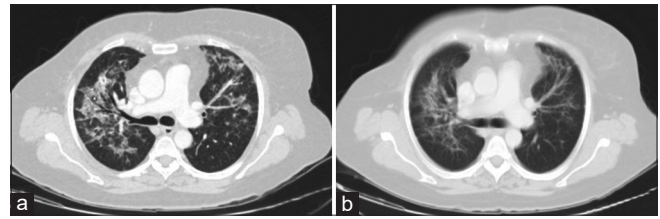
High-resolution computed tomography images of residual response to steroid in taxane-induced interstitial lung disease. (a) Baseline high-resolution computed tomography of the thorax showing drug induced interstitial pneumonitis following docetaxel with interstitial septal thickening and alveolar opacities in bilateral lung fields, more on the right side. (b) Residual lung lesions after steroid therapy with ill-defined patchy alveolar opacities and septal thickening in bilateral lung parenchyma
